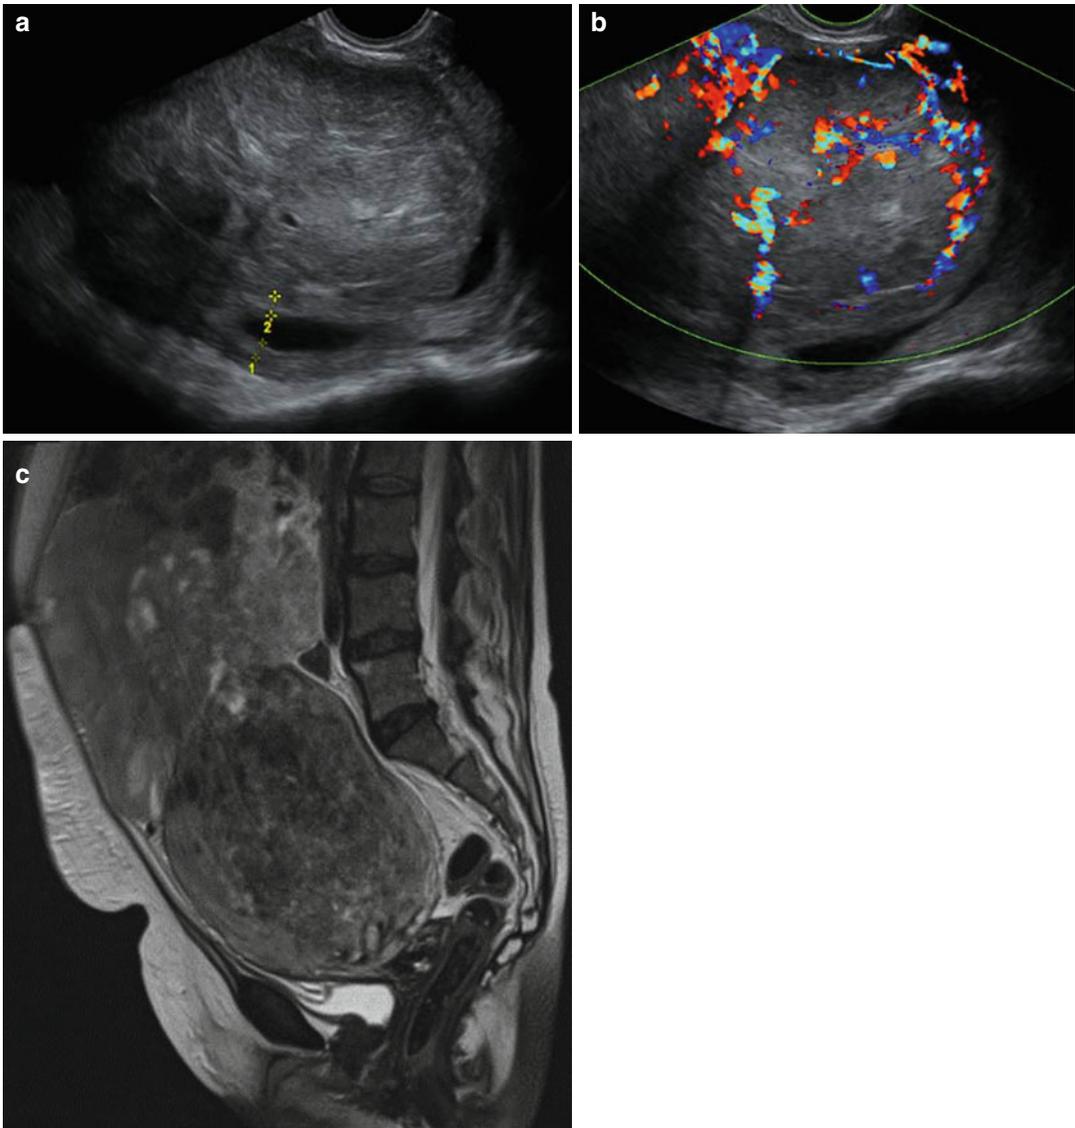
(a) Greyscale ultrasound scan of uterus with leiomyosarcoma. The endometrial thickness is measured between the markers. 1 and 2 show the measurement of both endometrial layers. Besides fluid in the uterine cavity several lacunae can be seen. (b) Ultrasound greyscale
